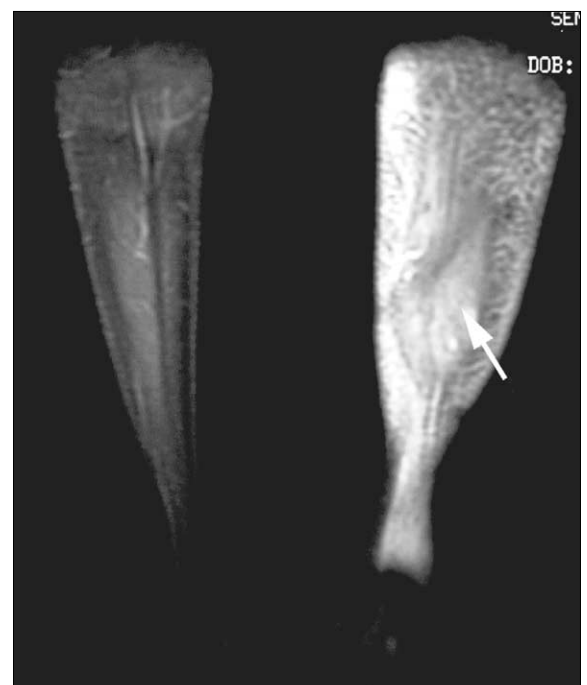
Coronal T1-weighted magnetic resonance images without contrast through the right and left lower legs of an HIV-infected patient 2 weeks after starting HAART
